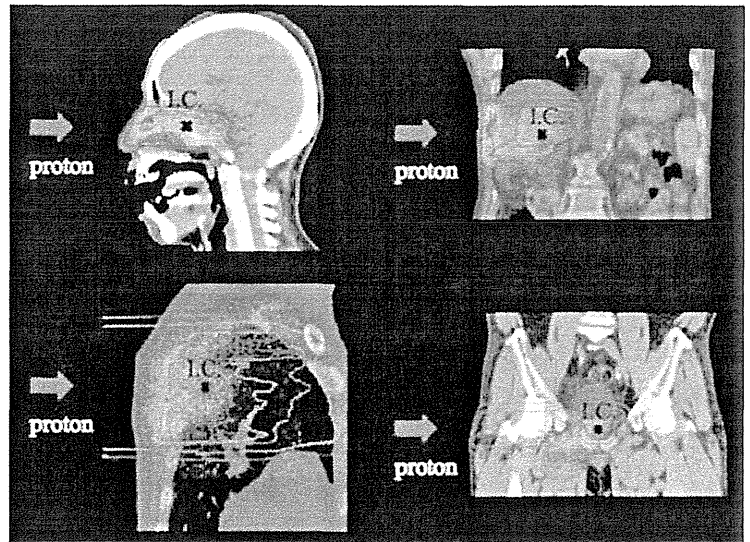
Proton dose distribution calculated with the proton treatment planning system and activity distribution measured with the BOLPs-RGp on CT image each treatment site.¹⁰⁾
